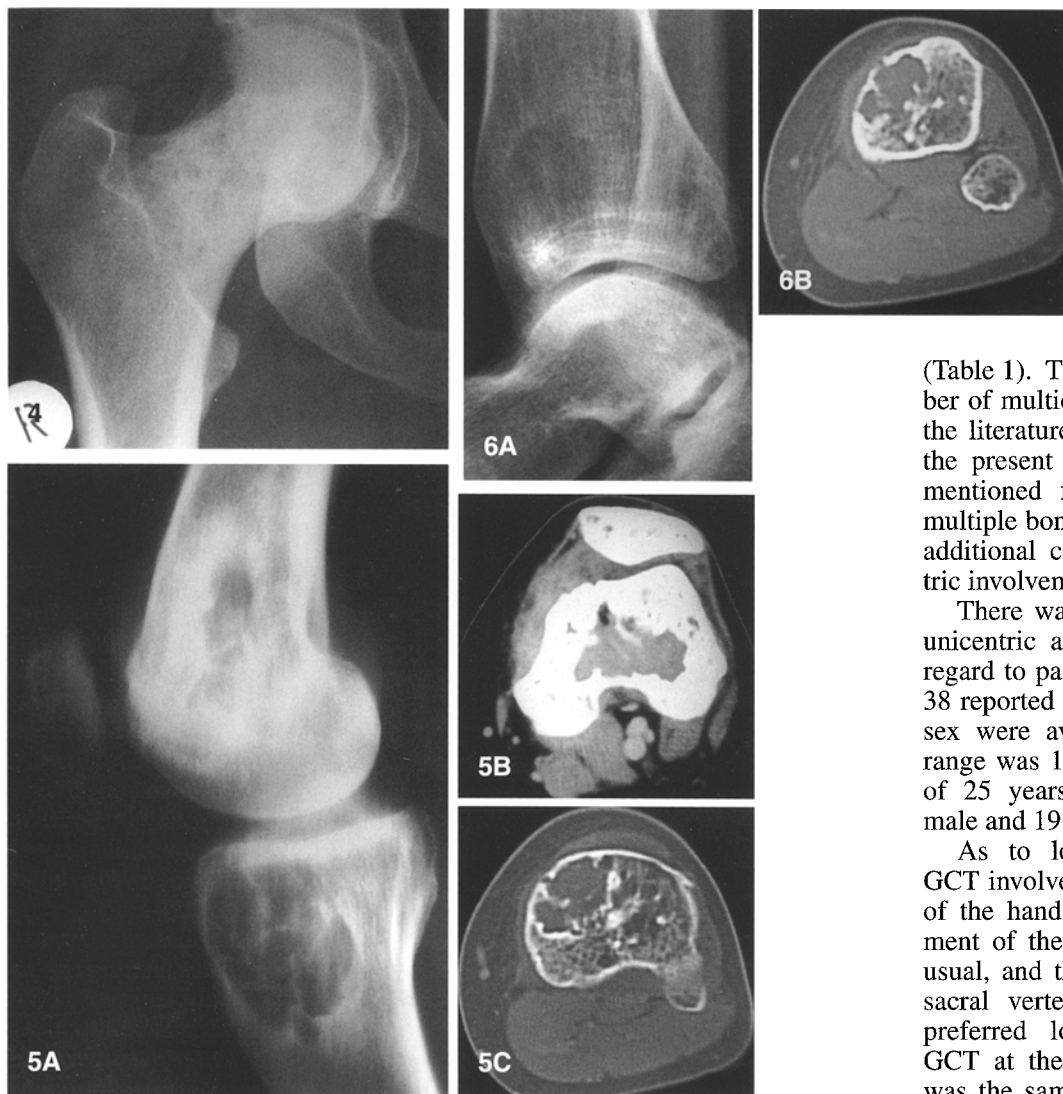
Anteroposterior radiograph of the proximal femur in 1990 at the time of admission shows an osteolytic area in the femoral head and neck
